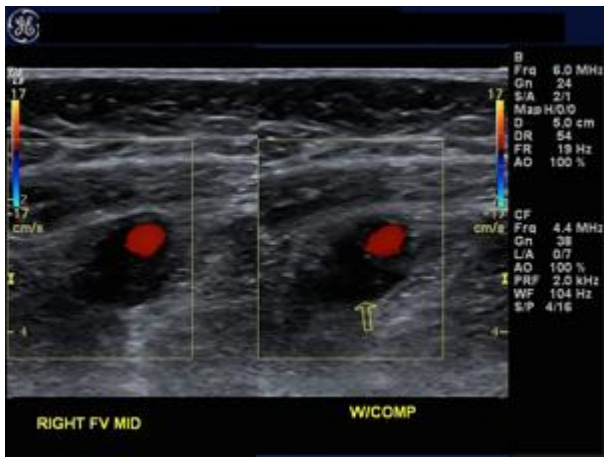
Color Doppler image of the mid right superficial femoral artery and vein
